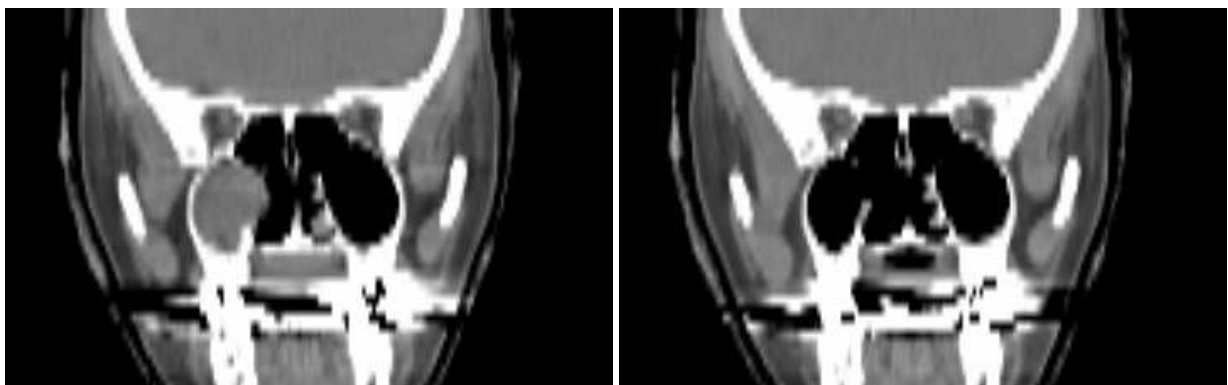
The same comparison as in figure 3–8 between the planned (top, left) and recalculated dose distribution with the modified CT (top, right) for the examined case (b). The maximum dose values of the original and recomputed fields were about 650 mGy. The maximum and minimum values for the difference between the recalculated and planned dose distributions (bottom) were found to be 495 mGy and -200 mGy.*
